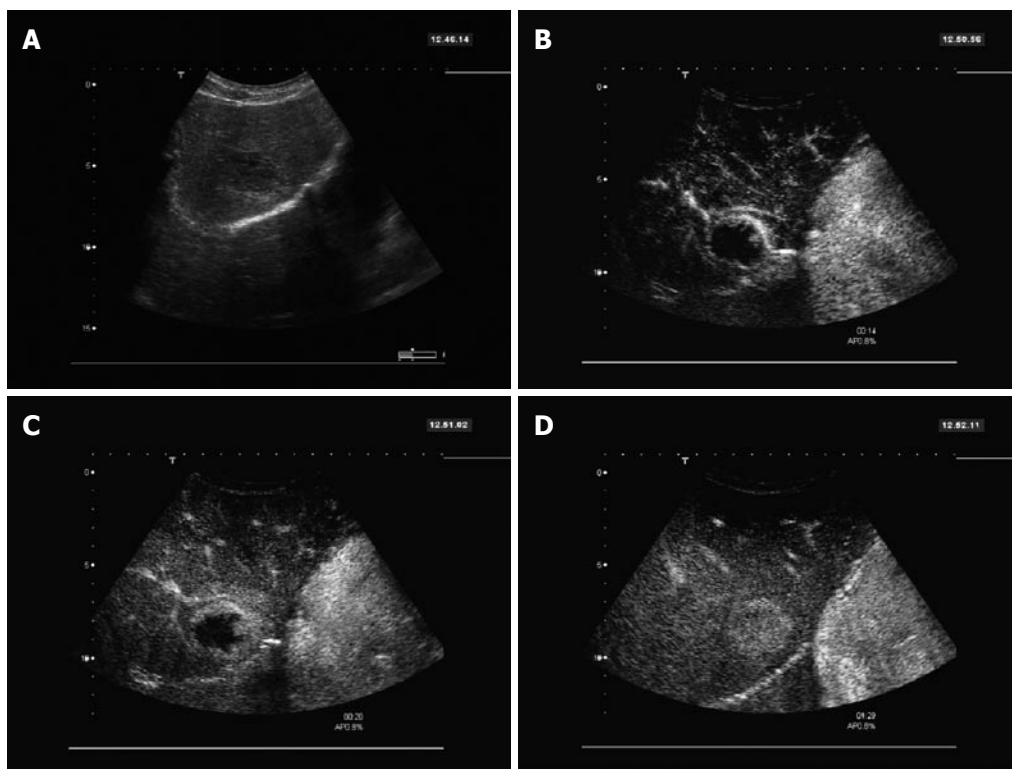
36-year-old female. A: 4.0 cm hypoechoic lesion in segment 8 found in B-Mode sonography; B: Contrast-enhanced sonography with SonoVue® showed a peripheral enhancement with nodular contrast accumulations 14 s after injection; C: Slow progression of the enhancement from the periphery towards the center of the lesion, with a broader peripheral enhancement zone seen at 20 s; D: After 1.5 min, the lesion is completely filled with contrast and appears hyperenhanced compared to the surrounding normal liver tissue. The enhancement pattern is typical for a hemangioma.
